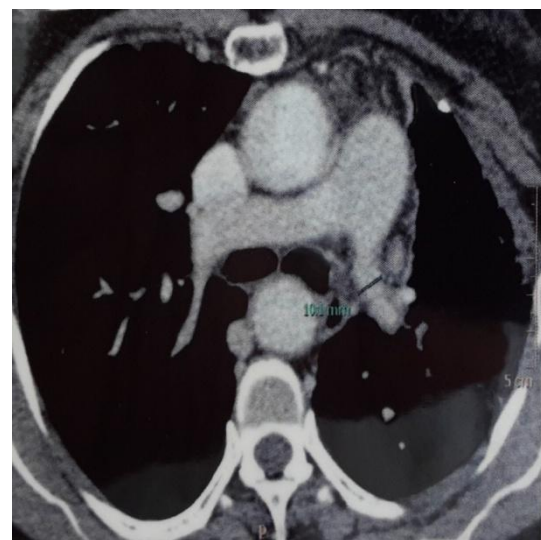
Computed Tomography showing a decrease in the size of left main pulmonary artery.
